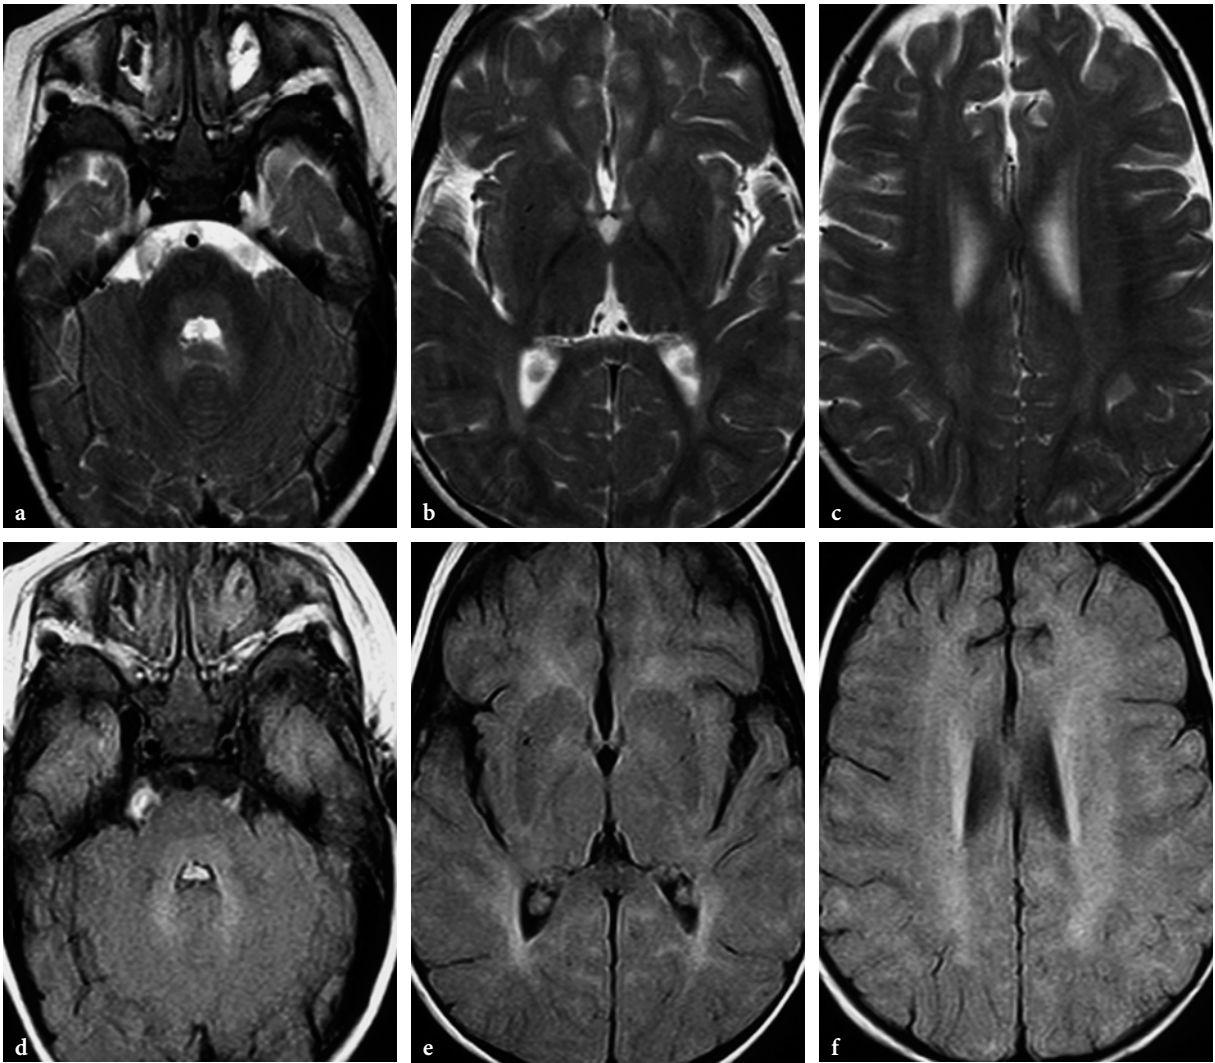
MR imaging findings in a 19-month-old girl with Gaucher disease type 2 (courtesy of Dr. P. Tortori-Donati, Genoa, Italy). a–c Axial T2-weighted fast spin-echo images; d–f. axial FLAIR images. There is a mild hyperintensity of the periventricular and deep central white matter that spares the subcortical U fibers (c). Notice that the globi pallidi are slightly hyperintense, whereas the capsules are spared (b). Also notice mild hyperintensity of the pontine tegmentum and dentate nuclei (a)
